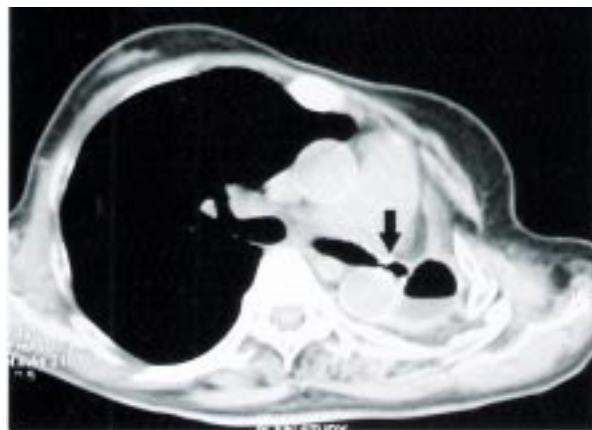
CT scan axial section (mediastinal window) showing empyema with air fluid level. Note the presence of surgical clips around the left bronchial stump (arrow).
